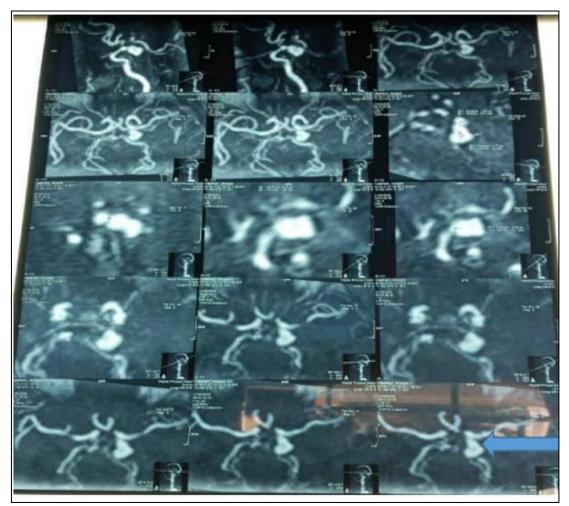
MRI angiography showing a saccular aneurysm of the left posterior communicating artery
